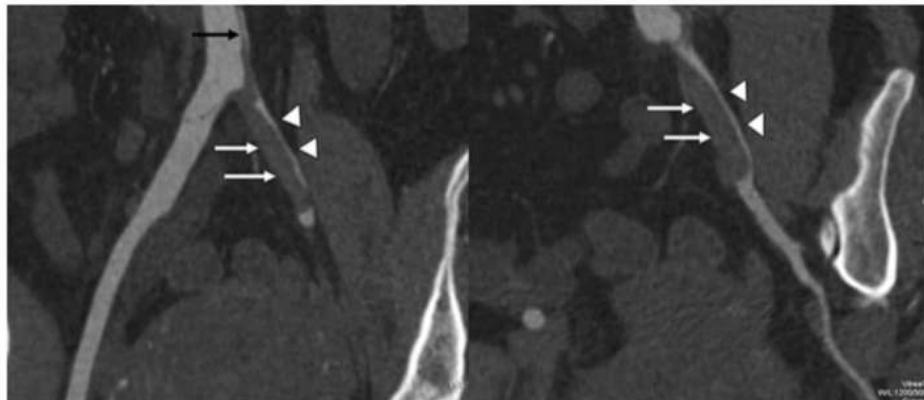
Coronal reconstruction of a computed tomography angiography study with images of the aortic bifurcation and iliac arteries in a 45-year-old man with acute dissection complicated by left leg ischemia. In this case, there is static involvement of the left iliac artery with extension of the plane of the dissection septum from the left side of the aorta into the branch (black arrow); however, unlike the static involvement detailed in Fig. 6, the false lumen within the left iliac branch does not re-enter with a terminal tear. This lack of distal false lumen communication within the involved branch causes a “no re-entry” phenomenon often associated with no blood flow or clot within the blind cul-de-sac of terminal false lumen (white arrows). This is commonly associated with near obliteration of the true lumen (white arrowhead) by the expanded, stagnant false lumen within the branch. The lack of false lumen branch flow and severe compromise of limb viability are complications frequently accompanied by critical ischemia that may lead to irreversible tissue damage in the distal vascular bed.
